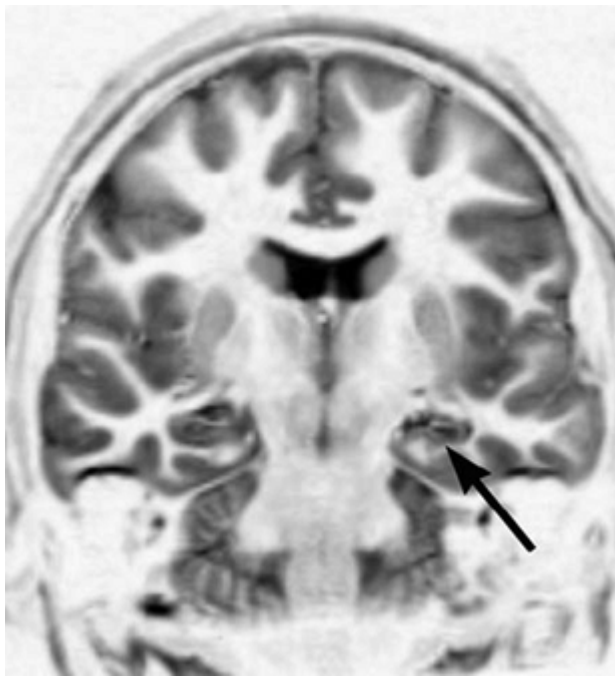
Classic hippocampal sclerosis (HS). Note the small hippocampus, with abnormal T1-weighted signal (*dark*) and no normal internal features (*arrow*). The hippocampus on the other, contralateral, side shows clearly demonstrated internal features. In this case the CA1 and dentate show decreased signal. This is also the case in heavily T1-weighted images in normal controls, suggesting that these neuronal parts have special imaging properties. In this case, this is more than is usual, suggesting that there may be minor changes in the contralateral hippocampus in these areas. This patient had a prolonged febrile convulsion at the age of 9 months and now has temporal lobe epilepsy.
